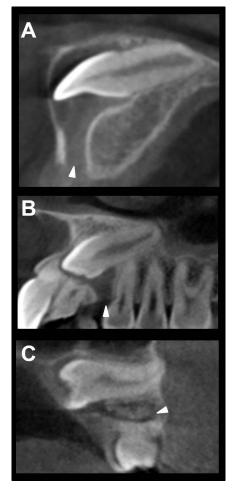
CBCT images of examples of unusual attachment sites of the gubernacular canal (GC) to the dental follicle. (A) Upper anterior tooth with delayed eruption exhibiting CG attachment in the lingual (bucco-lingual aspect) and central (occlusal-cervical aspect) regions of the dental follicle. (B) Impacted upper anterior tooth showing attachment of the GC to the dental follicle in the cervical portion of the crown. (C) Impacted upper premolar exhibiting unusual GC attachment in the cervical region of the crown. Arrows indicate the GC.
